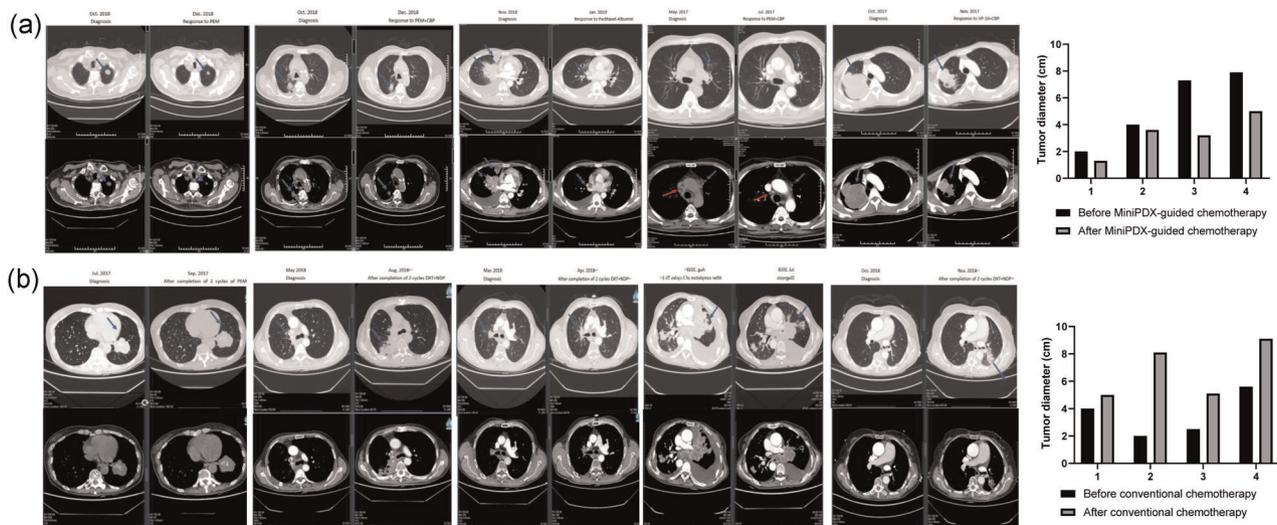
Chest CT scans before and after chemotherapy. (a) Tumors before and after MiniPDX-guided chemotherapy; (b) tumors before and after the conventional chemotherapy; (c) change in tumor diameter before and after chemotherapy. The upper and lower images showed the nodules in the lung and mediastinal windows, respectively. The blue arrow indicated tumor in lung, and the red arrow indicated lymph node. CT, computed tomography
